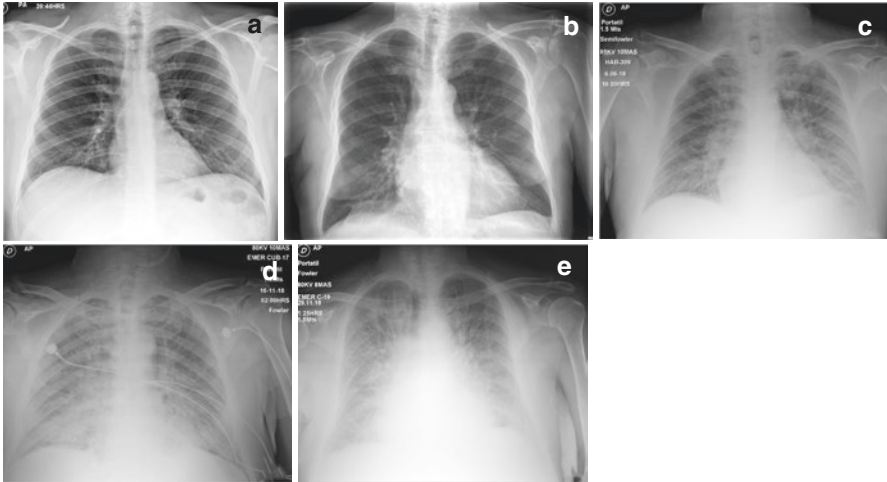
Image a depicts a chest X-ray with normal pulmonary circulation. Image b has venous hilum and flow redistribution. Image c shows signs of interstitial edema. Image d has alveolar edema predominantly on the basal portion of the right lung. Image e has severe bilateral alveolar edema
